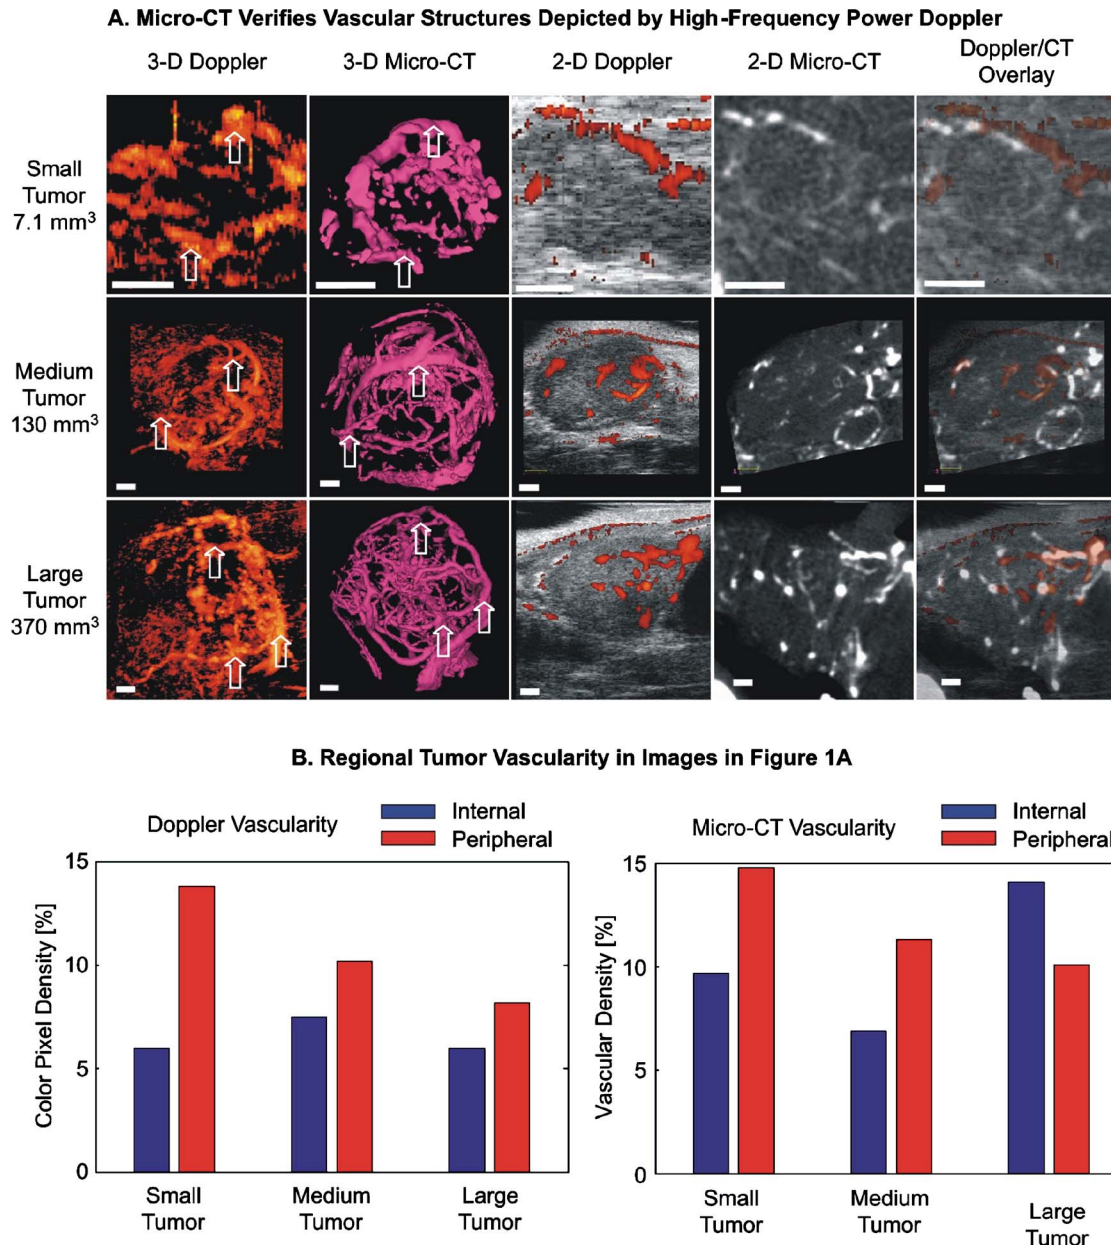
Power Doppler ultrasound images of vasculature in a GEM-prostate cancer model are verified by Microfil-enhanced micro-CT. (A), from left to right in the first row, a three-dimensional power Doppler image, a three-dimensional micro-CT image, a two-dimensional plane from the three-dimensional power Doppler image, the matching two-dimensional plane from the three-dimensional micro-CT image, and an overlay of the two-dimensional power Doppler and micro-CT images of a 7.1 mm³ tumor. Second and third rows, equivalent sequences of images from a 130 mm³ tumor and 370 mm³ tumor, respectively. Arrows, sites used for registration of corresponding vessels. Bars, 1 mm. (B), bar graphs of internal and peripheral vascularity estimated from the three-dimensional power Doppler and micro-CT images shown in (A). The power Doppler and micro-CT vascularity metrics (CPD and vascular density, respectively) are shown on separate graphs. Adapted from Xu *et al.* (Ref. 201).
